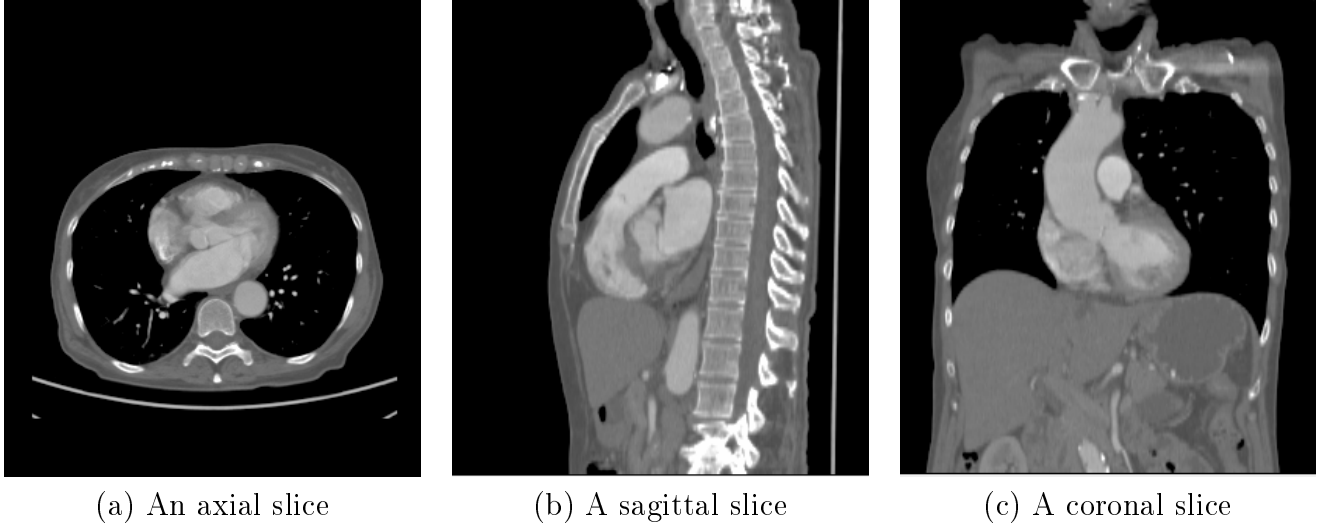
An example of diagnostic CT scan of the chest. The axial, coronal and sagittal slices are extracted from a three dimensional scan.
